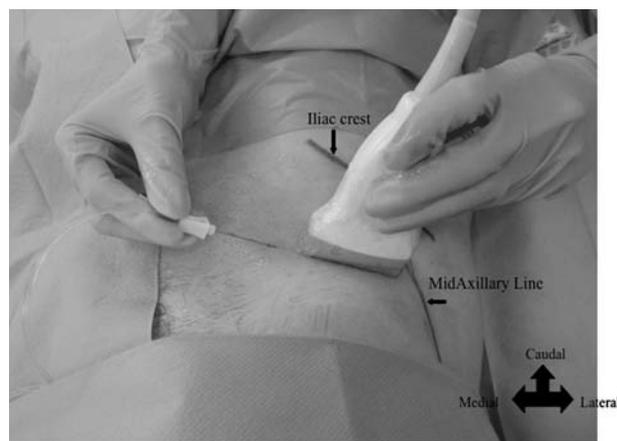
In-plane TAP block puncture under ultrasound guidance. The probe is placed cephalad to the iliac crest, transversally in the midaxillary line. The puncture is realized with a 50-mm, 22-gauge needle (Nanoline; Pajunk) in the plane of the probe.
